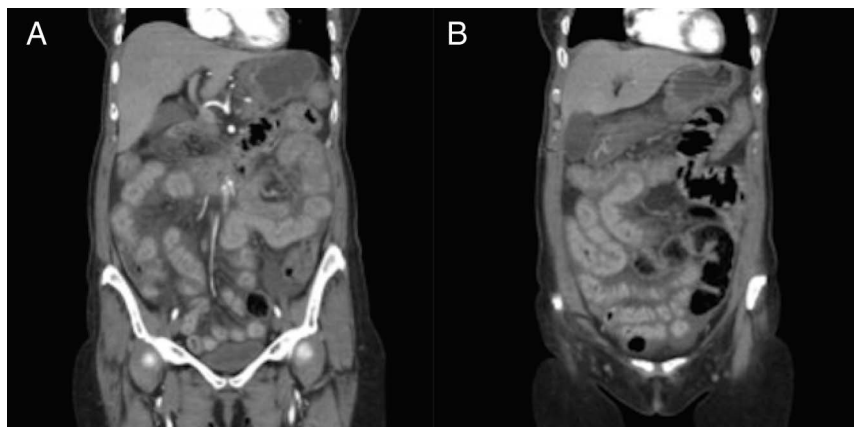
Abdominal and pelvic computed tomography showing (A) diffuse thickening of the small bowel and colonic walls and (B) the presence of mucosal enhancement and submucosal edema.
